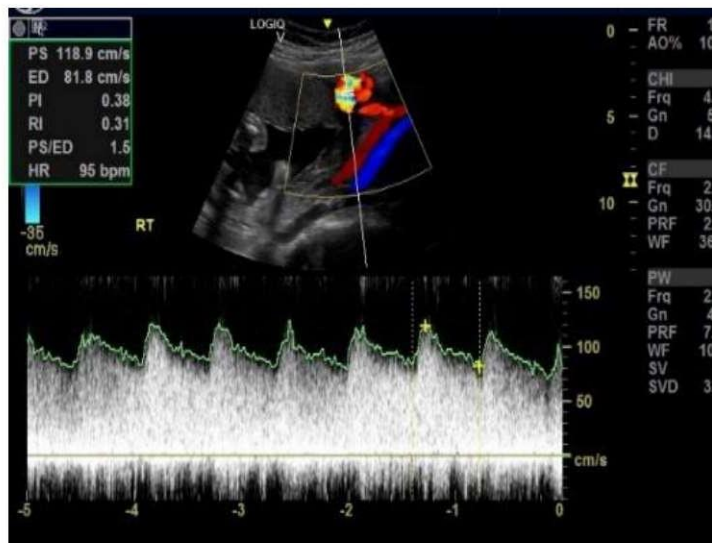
Normal uterine artery Doppler flow tracing
